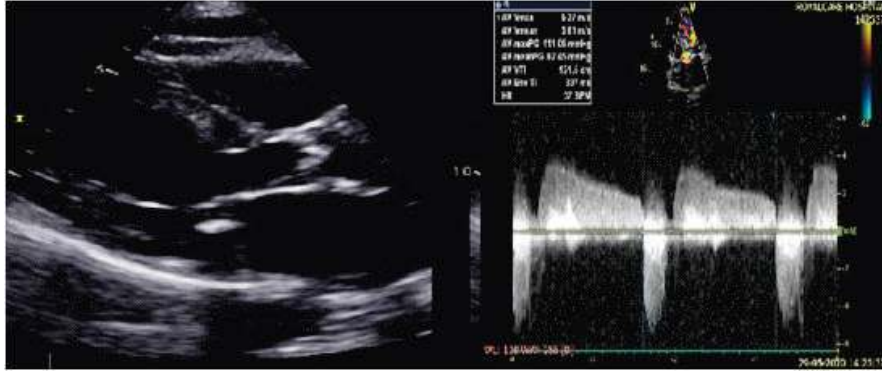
Echocardiogram showing restricted aortic valve opening with severe AS in doppler
